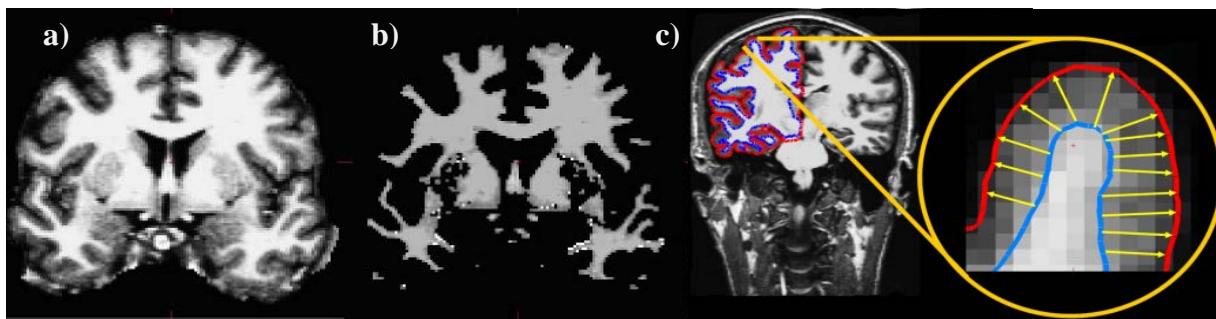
Different VBM preprocessing steps over the T1-MRI structural images.
